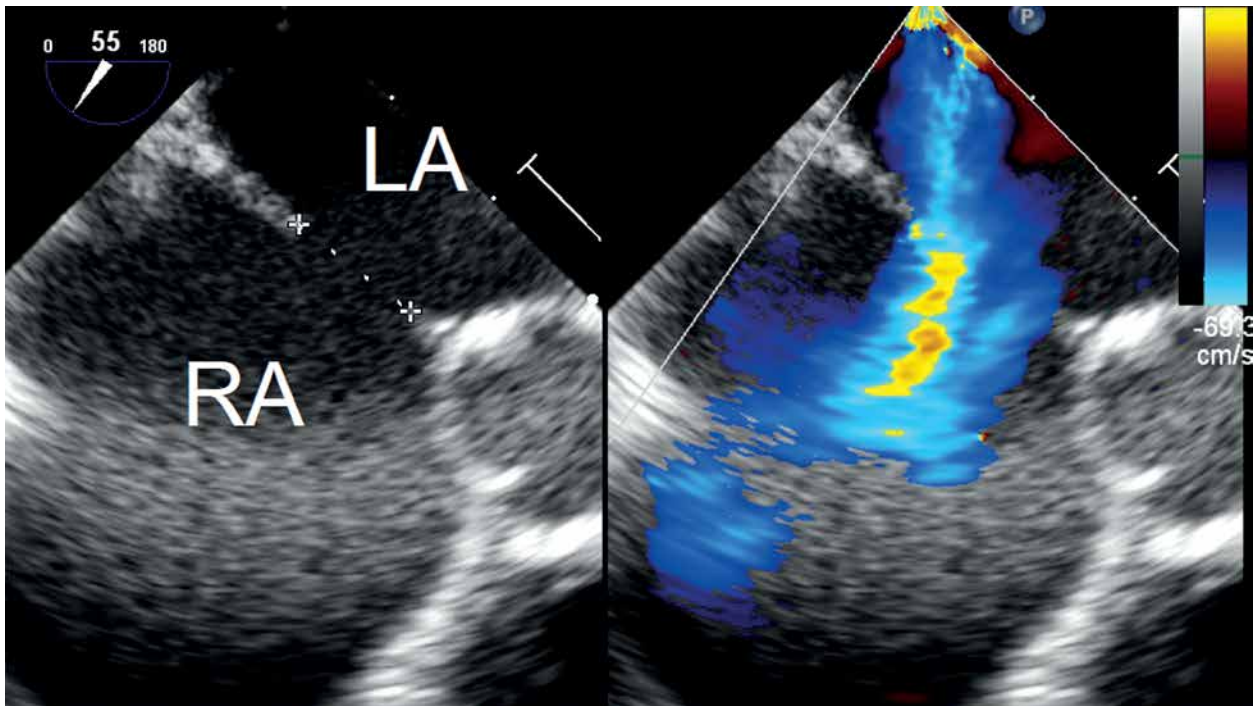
Transesophageal echocardiography with color Doppler. Atrial septal defect with left-to-right shunt
